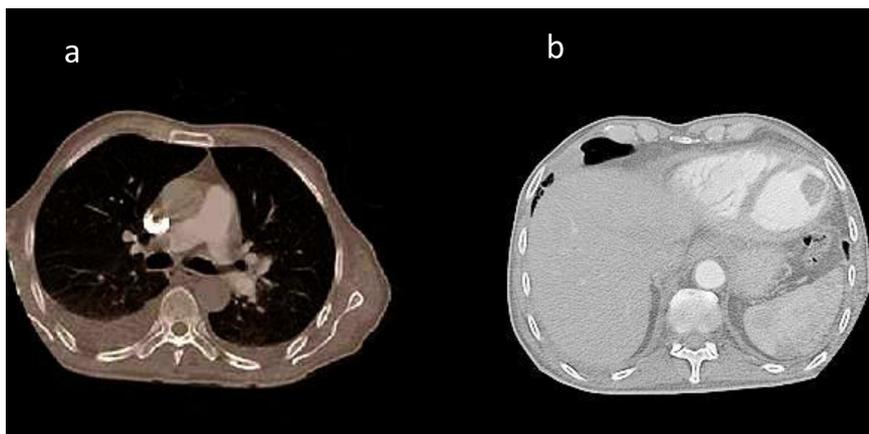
a). Urgent chest CT-scan confirmed the clinical diagnosis of severe pulmonary embolism. b). In addition, a “deficit” in the left ventricular apex was noted.
